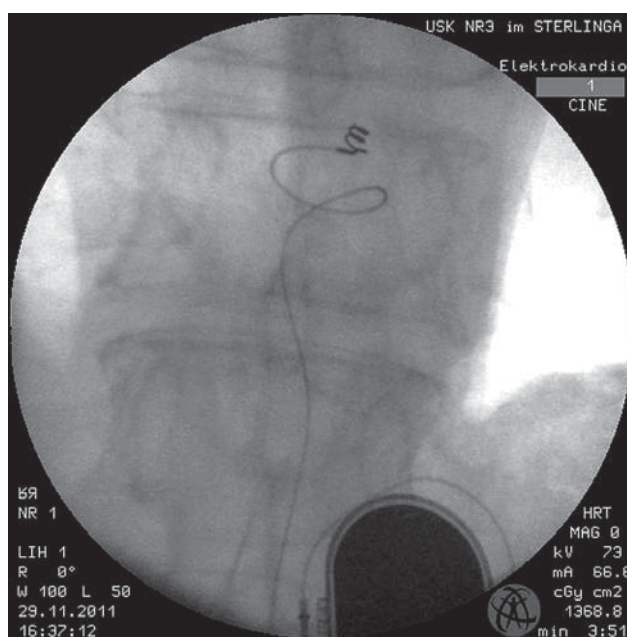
The X-ray image of the implanted system
